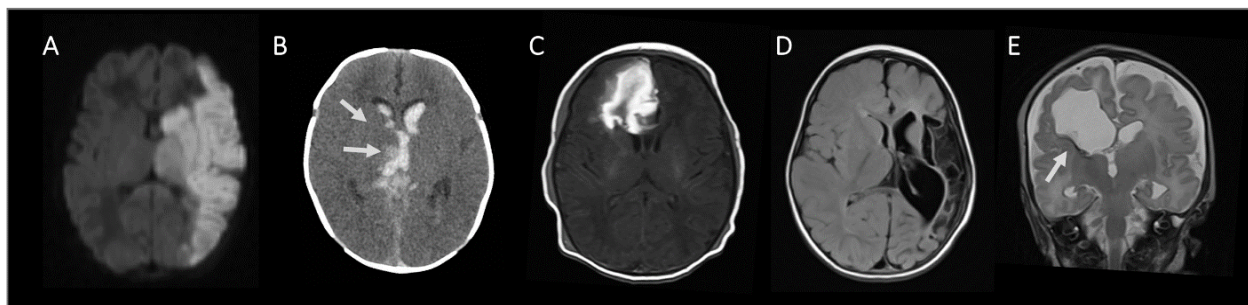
Perinatal stroke imaging. (A) Neonatal arterial ischemic stroke (NAIS) as seen on axial diffusion weighted imaging (DWI). (B) CT shows intraventricular hemorrhage in a term baby due to deep CSVT. Note primary hemorrhagic infarct in right thalamus (arrow) and edema in basal ganglia (top arrow). (C) Neonatal hemorrhagic stroke (NHS) as seen on axial T1-weighted sequence. (D) Arterial presumed perinatal ischemic stroke (APPIS) with focal encephalomalacia in left MCA territory seen on axial FLAIR. (E) Periventricular venous infarction (PVI) as seen on coronal T2-weighted sequence. Note remote blood product in subventricular zone (arrow).
